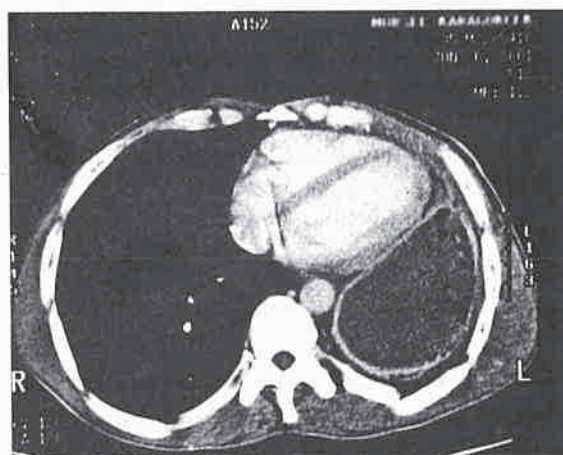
Computed tomographic scan of chest showing fluid collections of pleural empyema.
